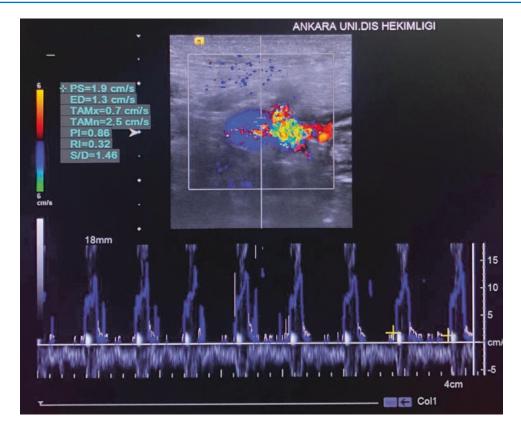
Example of aliasing artifact in Color Doppler in triplex mode
